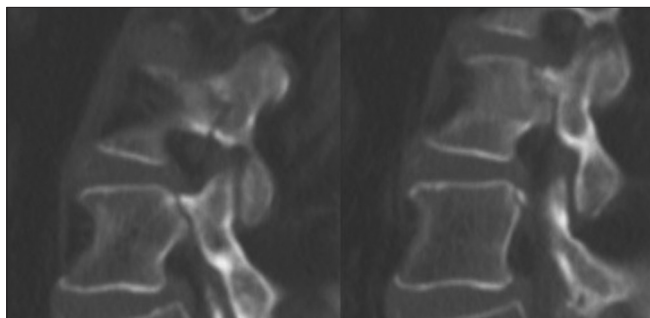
Sagittal computed tomography of left L2 and L3 pedicles demonstrating complete pedicle fracture
